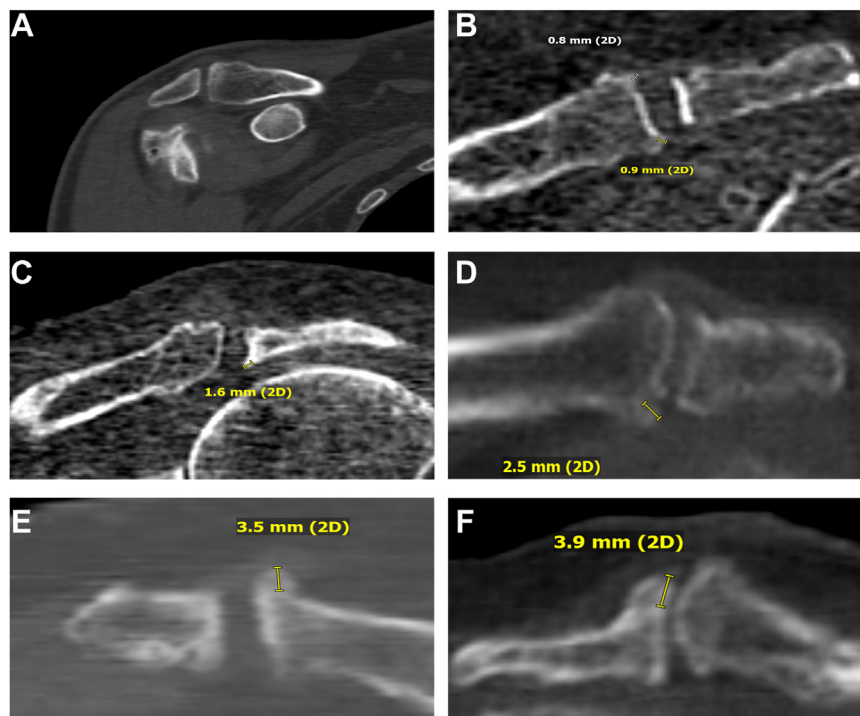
King classification of acromioclavicular joint arthritis based on osteophyte measurement on computed tomography. (A) Grade 1. (B) Grade 2. (C) Grade 3. (D) Grade 4. (E) Grade 5. (F) Grade 6.
